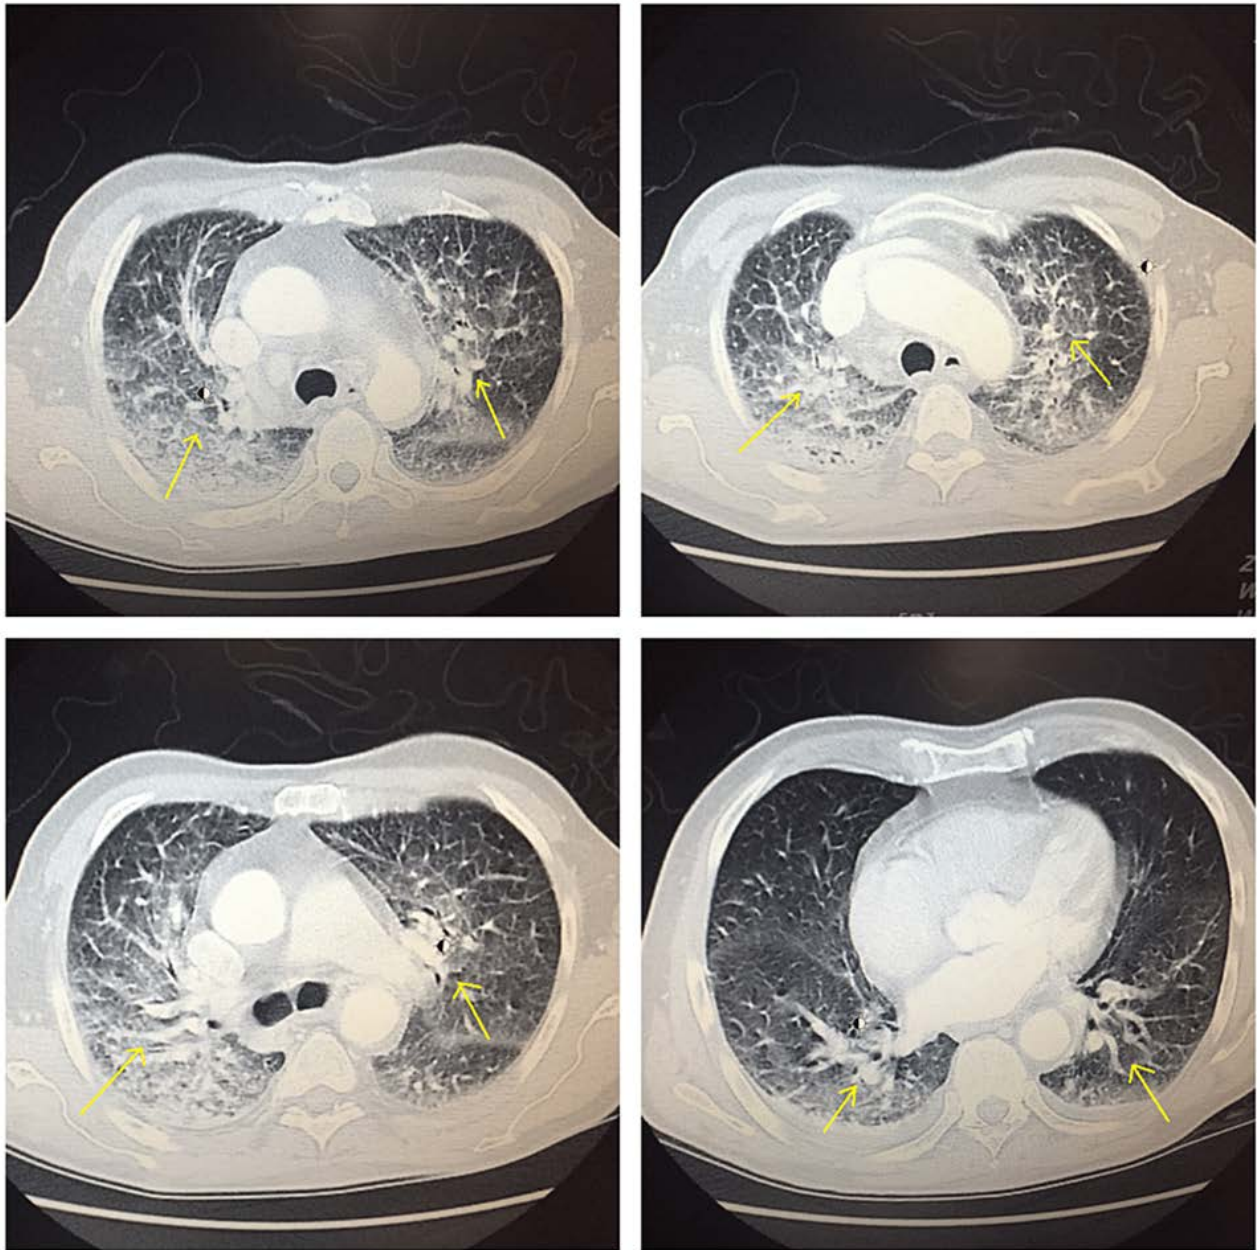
CT Chest with Contrast: Diffuse bronchiolectasis. Diffuse patchy consolidation predominantly subpleural and peribronchial in distribution. Bronchial wall thickening. These findings are consistent with cryptogenic organizing pneumonia
